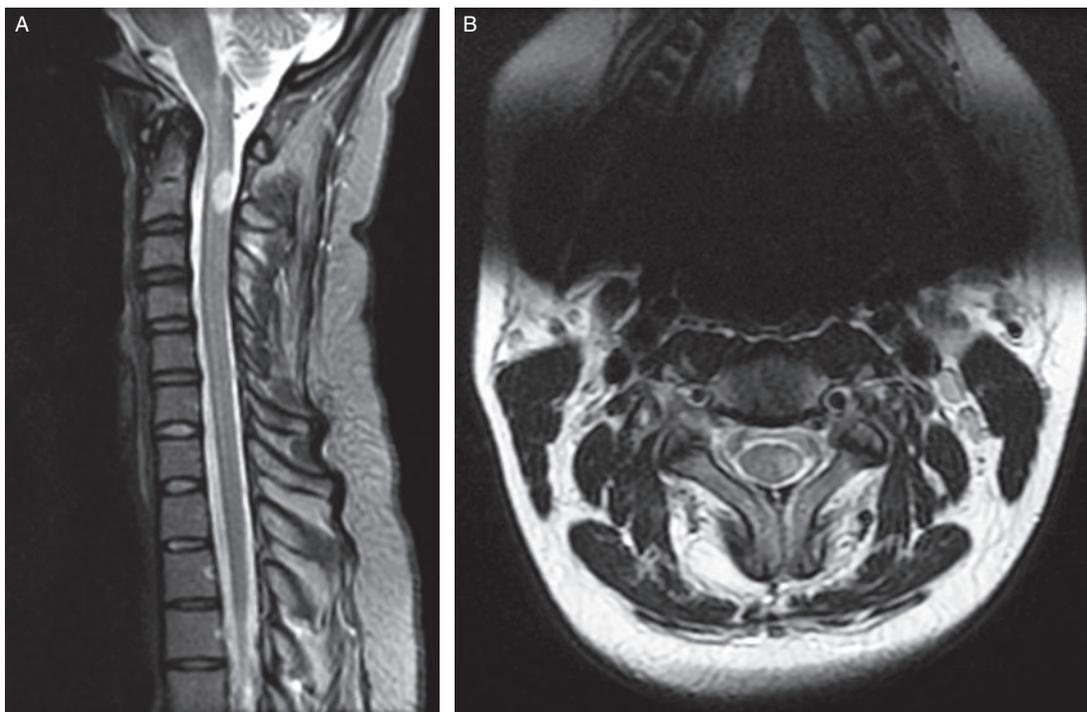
Sagittal T2 MRI cervical spine dorsally placed, short-segment, ovoid lesion characteristic of multiple sclerosis. Axial T2 MRI cervical spine in the same patient shows the lesion is in the left lateral aspect of the spinal cord.
